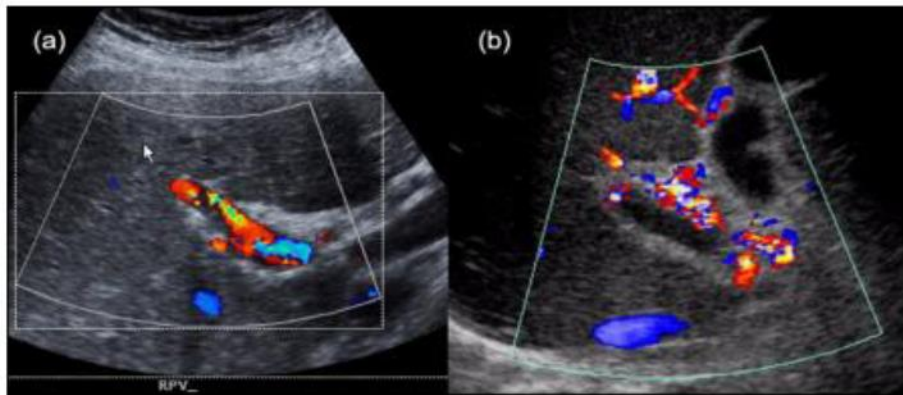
(A) Doppler ultrasound of the abdomen showing partial thrombosis of the portal vein.(B) Doppler ultrasound of the abdomen showing complete thrombosis of the portal vein [15].
